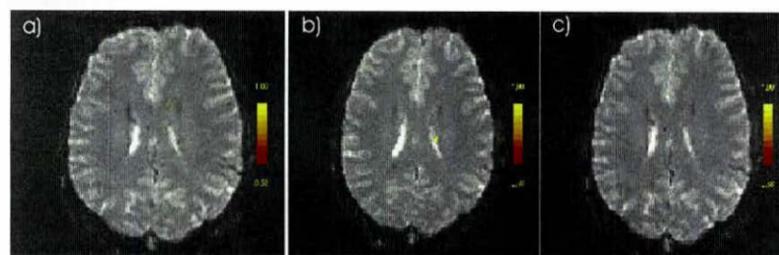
Cortical activation within the Globus Pallidus GP a) prior to DWI, b) immediately after DWI and c) one week after DWI. In CMT study, a small but sharply delineated activation focus within the medial GP ipsilaterally to the tapping left hand can be discovered, which is absent in first and second test motortask TMT.
